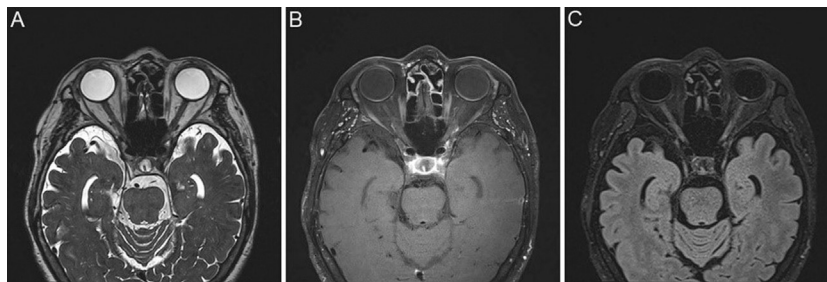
Orbit magnetic resonance imaging of a 70-year-old female patient with non-arteritic ischemic optic neuropathy (Case 1) Axial 3D T2-weighted SPACE and contrast-enhanced T1-weighted image demonstrate no definite optic disc swelling or contrast enhancement at the left optic disc (A and B, respectively). Axial contrast-enhanced 3D T2-fluid-attenuated inversion recovery image demonstrating definite focal contrast enhancement at left optic disc (C).
